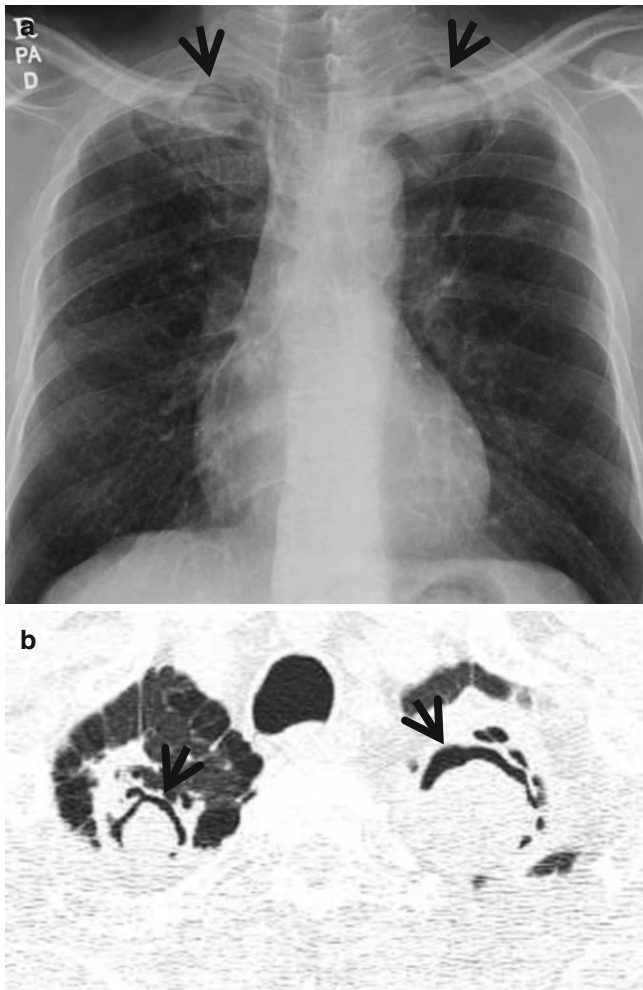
Air-crescent sign in aspergillomas growing within chronic tuberculous cavities in a 76-year-old man. (a) Chest radiograph shows air-crescent signs (*arrows*) in both apices. Also note small nodules in the bilateral upper lung zones. (b) Lung window image of thin-section (1.5-mm section thickness) CT scan obtained at level of great vessels demonstrates aspergillomas within cavities disclosing so-called air-crescent signs (*arrows*) in both lung apices. Also note parenchymal band in the right apex and bullae in both apices
